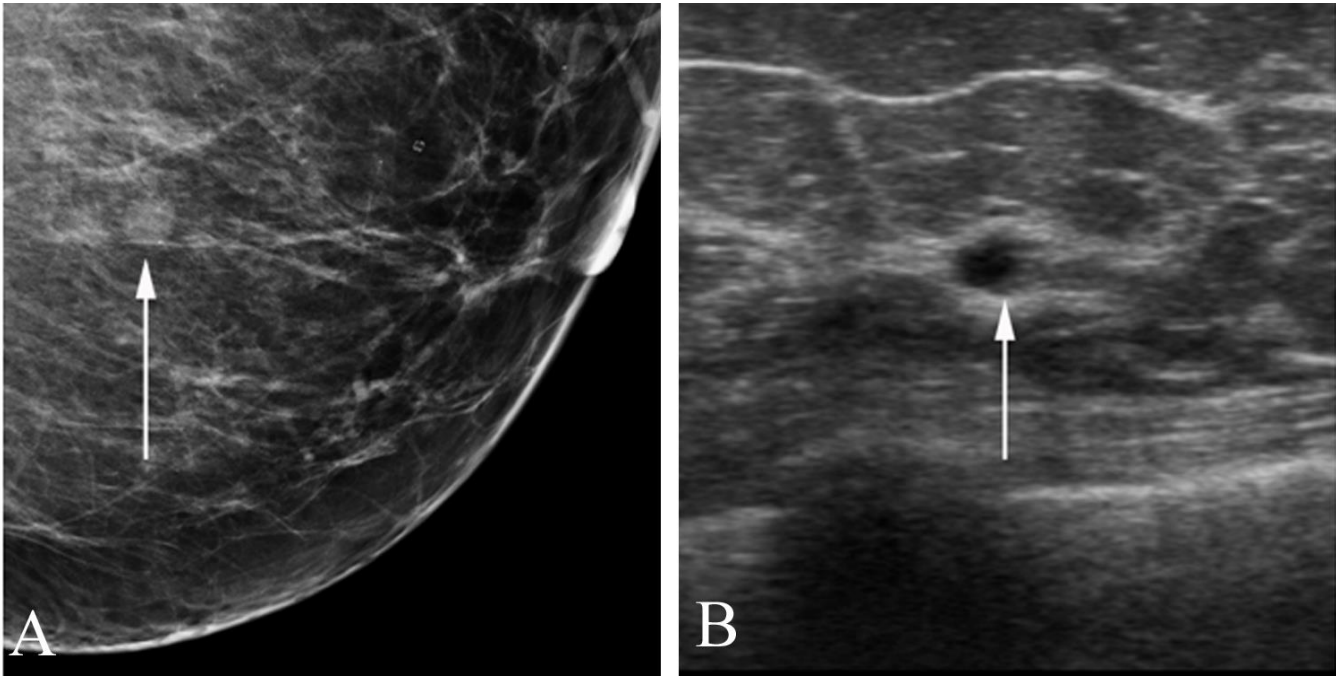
Cyst in a 47 year old woman with an abnormal screening mammogram, with ultrasound demonstrating a benign cyst at the location of the new lesion. A. Craniocaudal screening mammogram (cropped) shows a circumscribed hypodense lesion of the inferior right breast (arrow). B. Ultrasound (right) demonstrates a simple cyst at the location of the lesion (arrow), and no further work-up required.
